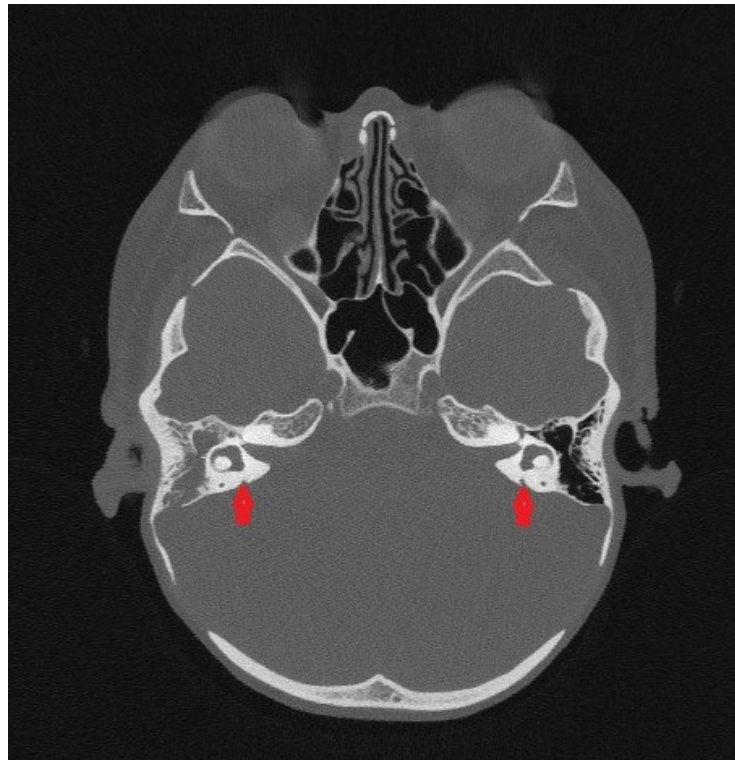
CT plain scan of the temporal bone. Red arrows point to the vestibular aqueduct was enlarged bilaterally, the size of the enlarged vestibular aqueducts was 2.2 mm.
